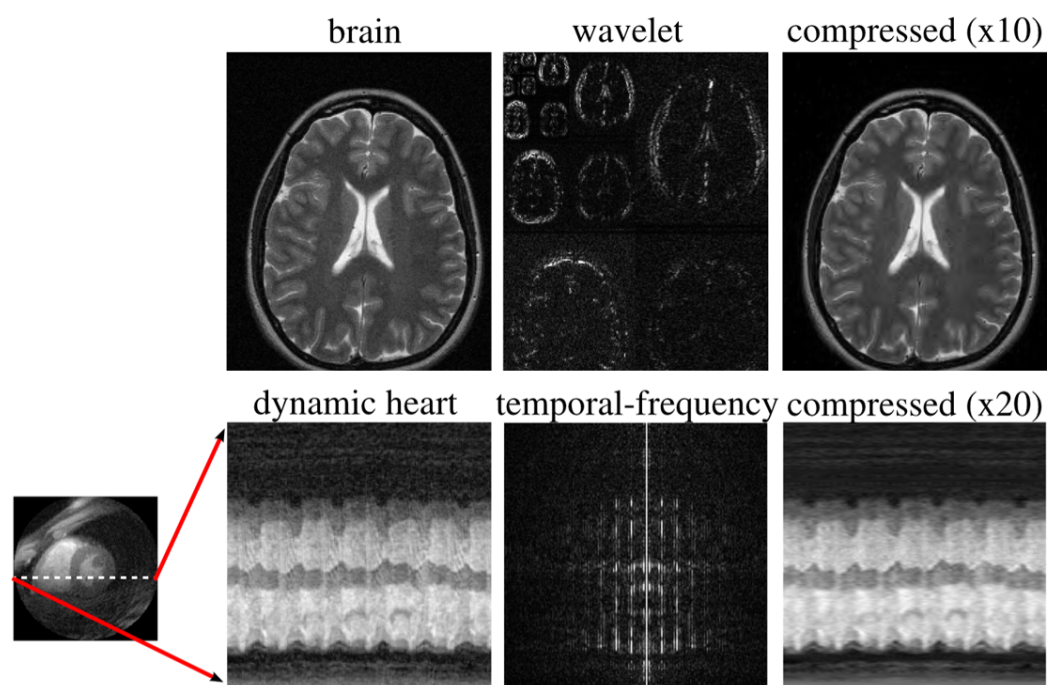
Transform sparsity of MR images. Fully sampled images (left) are mapped by a sparsifying transform to a transform domain (middle); the several largest coefficients are preserved while all others are set to zero; the transform is inverted forming a reconstructed image (right). Portions of figure originally appeared in [89]
